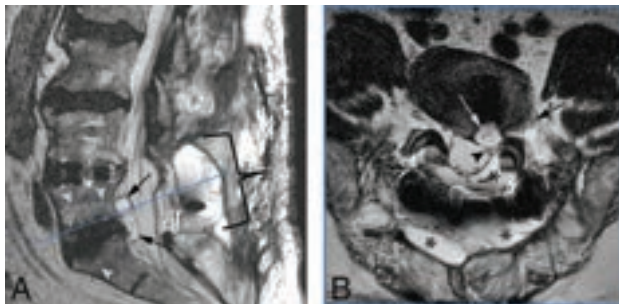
MR images in a 58-year-old man 2 months following BMP-augmented combined extreme lateral and posterior lumbar interbody fusion with laminectomy of L4–S1 and new-onset left foot drop. *A*, Sagittal T2-weighted MR image shows a lobulated epidural cyst at L5–S1 dorsal to the BMP graft (*black arrows*), endplate edema signal of the adjacent endplates (*arrowheads*), and the laminectomy defect with seroma formation (*bracket*). *B*, Axial T2-weighted MR image at L5–S1 (*dashed blue line*, *A*) demonstrates the left subarticular, epidural cyst (*white arrow*) adjacent to the BMP graft, abutting the left descending S1 nerve root (*arrowhead*) and the left exiting L5 nerve root (*black arrow*). Concomitant seroma is present and fills the laminectomy defect (*asterisks*).
